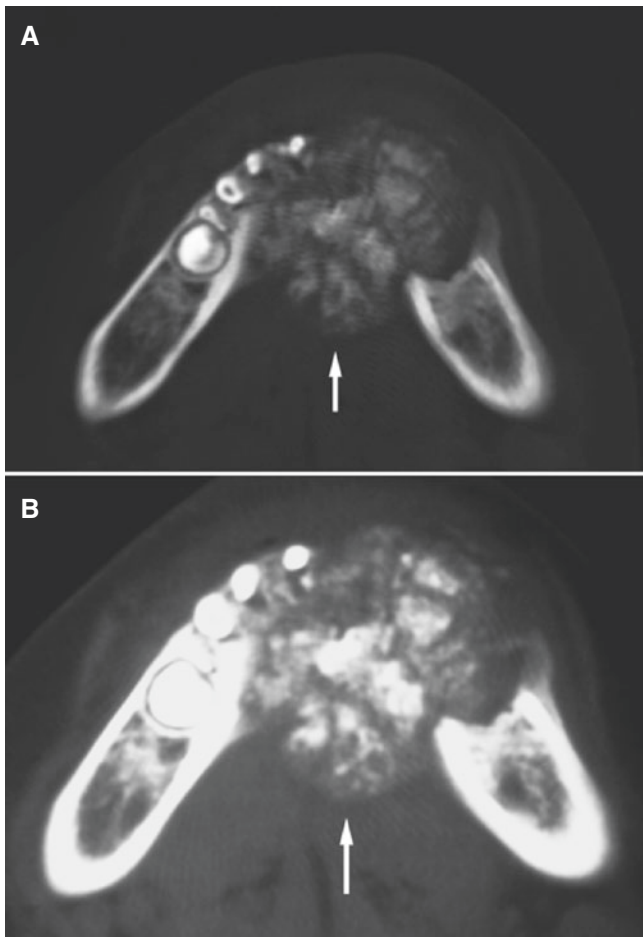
Osteoblastoma, mandible; 3-year-old male, painless swelling of the anterior part of the mandible. (A) Axial CT image shows extensive bone production (*arrow*). (B) Axial CT image, soft-tissue window, shows rather well-defined mass (*arrow*)
